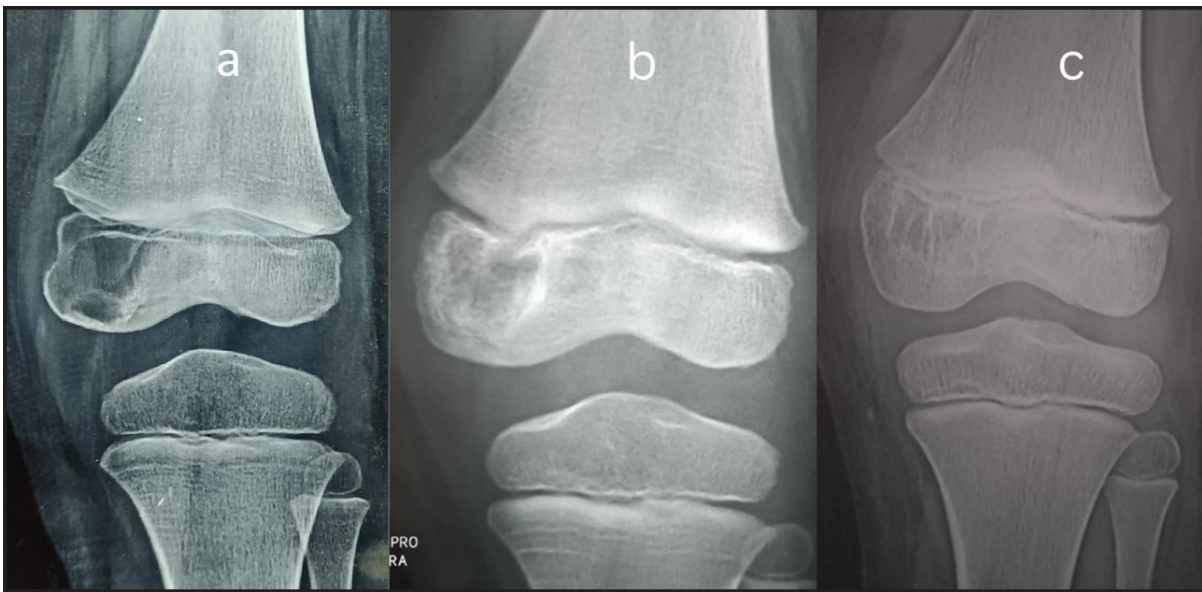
Radiographs showing an ABC affecting the left distal femur in a 3-year-old female child contained entirely in epiphysis: (a) before treatment, (b) at completion of treatment, (c) at 39 months after sclerotherapy
